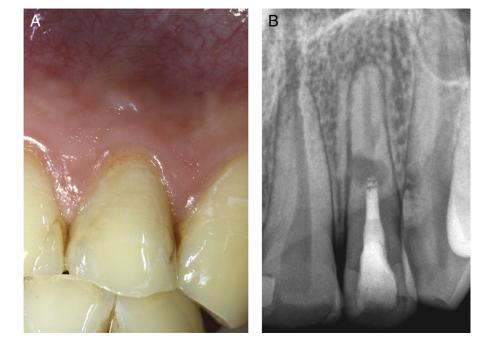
(*A*) Three months after regenerative endodontic treatment, the gingiva looks healthy. (*B*) Radiographic examination shows further reduction of the size of the apical radiolucency.
